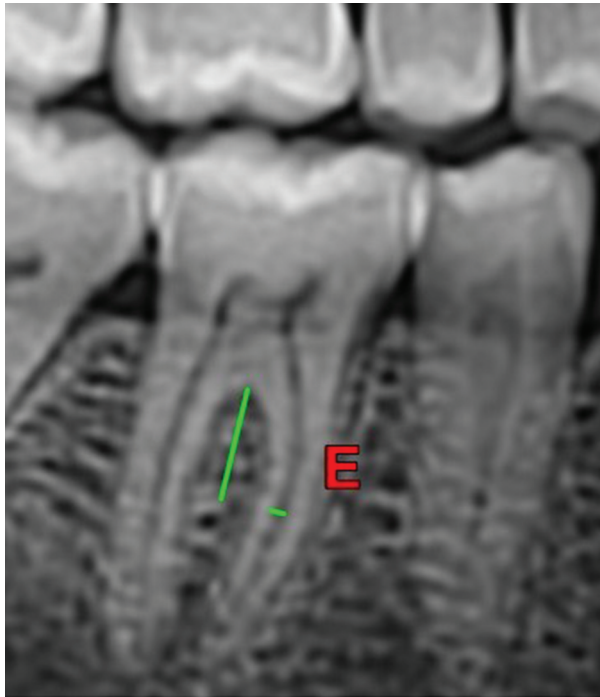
The distal root of left mandibular first molar measurements to calculate the novel method in panoramic radiography. Distal canal thickness was measured 4 mm below the furcation.
